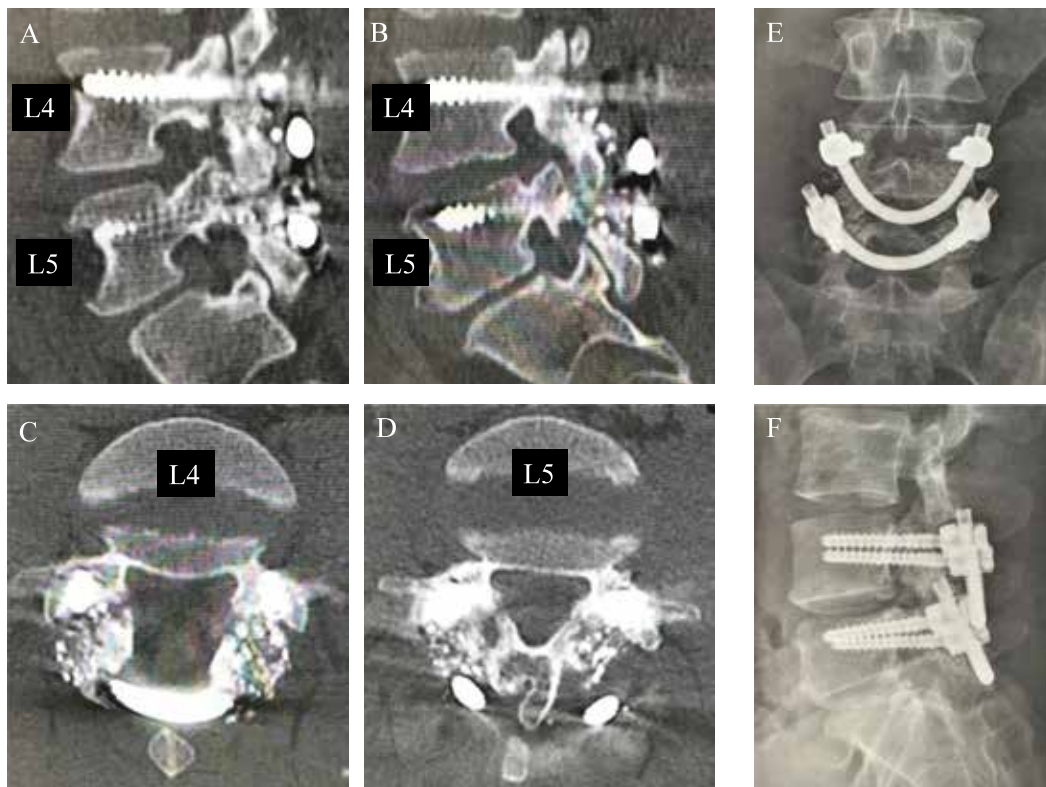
1 year after surgery, postoperative right para-sagittal (A), left para-sagittal (B), axial (C, D) and plain radiographs (E, F) at L4 and L5 showing the signs of bony consolidation in the pars defects with no screw loosening.
